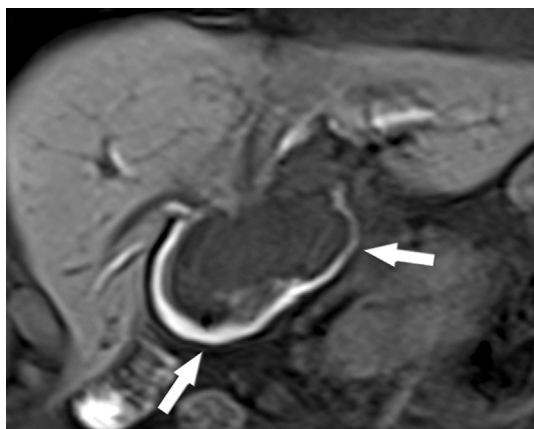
T1-weighted delayed image in the coronal plane after IV administration of gadoxetate disodium (Primovist®) shows hypointense endoluminal mass at the bilio-enteric anastomosis surrounded by the excreted contrast agent (arrows) which is hyperintense.
